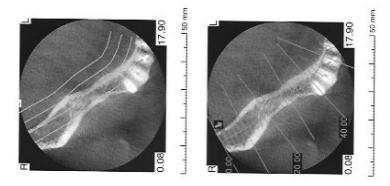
CT scan shows the horizontal defect.*
